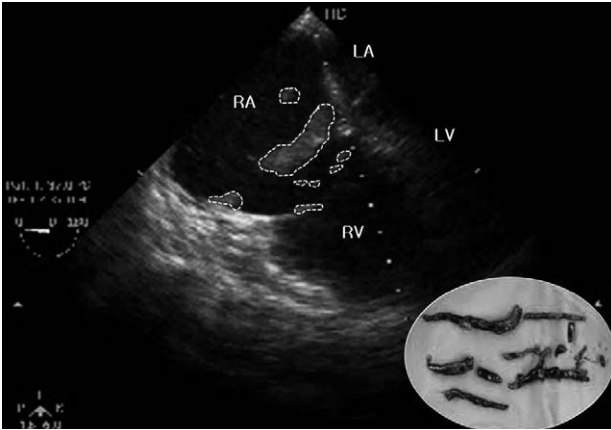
Transesophageal echocardiogram showing multiple thrombi on her right atrium and ventricle (dot) with severe dilatation of them. Evacuated thrombi (inset).
